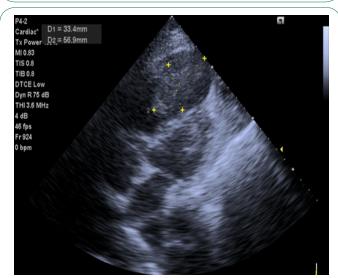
Echocardiogram showing 33.4 mm x 56.9 mm dimension of mass in right ventricular cavity.
